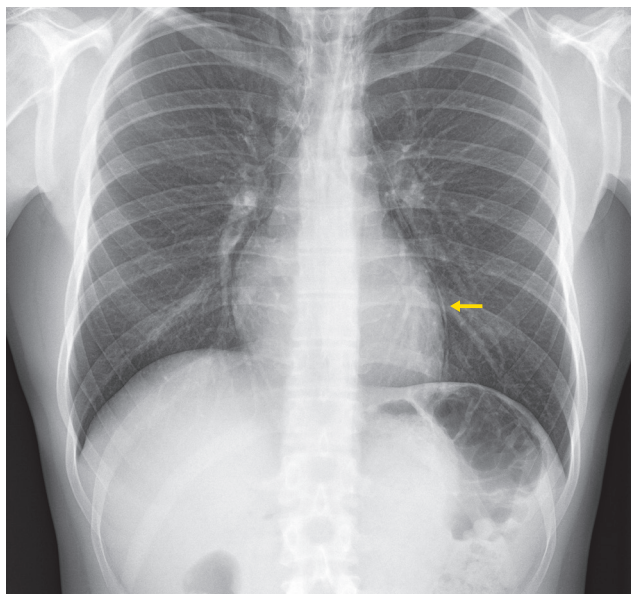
Radiography of the chest showing pneumomediastinum (yellow arrow)
